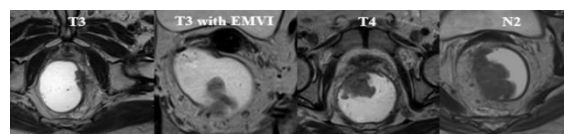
MRI T2W axial images of semi-annular morphology in T and N staging
